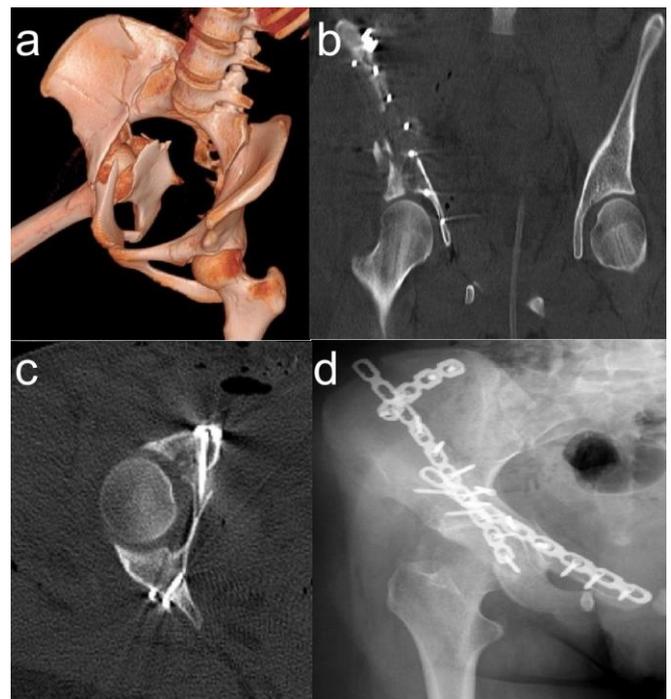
(a) Preoperative 3D computed tomography (CT) imaging of a 20-year-old female patient with a right acetabular fracture, quadrilateral surface involvement, and medial displacement of the femoral head. (b, c, d) Images demonstrating the quadrilateral surface stabilized with screws inserted through a suprapectineal reconstruction plate via a modified Stoppa approach.
